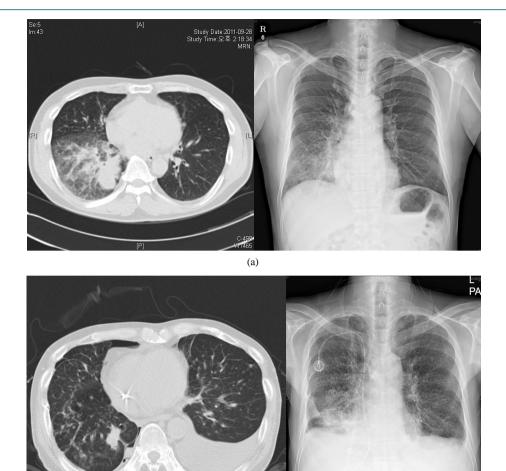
Chest X-ray and CT of 68-year-old female patient. (a) In February 2011, a huge tumor was observed in RUL with suspected chest wall invasion and pleural dissemination; (b) After 18 months of oncothermia with chemotherapy, follow-up exam in August 2012 showed marked regression of primary tumor.
